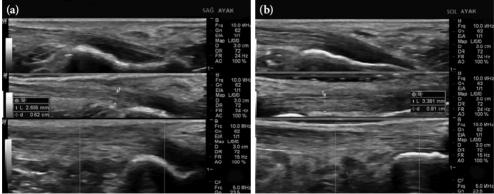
An ultrasonographic view of Achille's tendons: (a) right heel, (b) left heel. On left heel, tendinitis (thickening of the tendon, hypoechogenicity, disorganization of fibrillary pattern and 1+ Doppler signal) and cortical irregularity of calcaneus tendinitis were shown.
